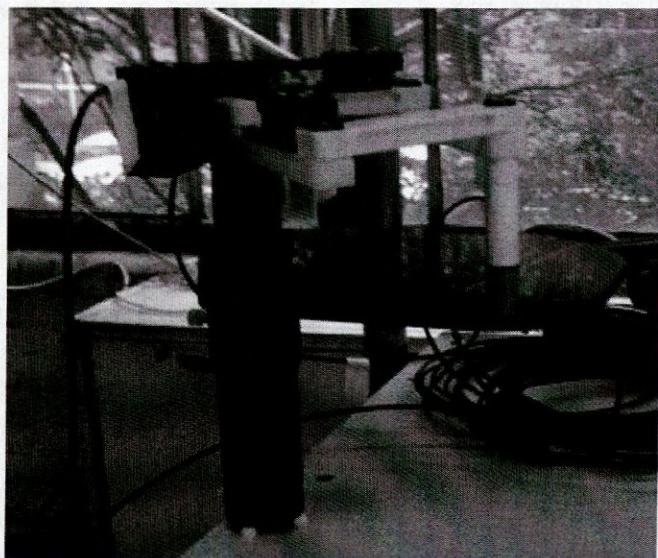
A two DOF MRI-compatible haptic device. Courtesy of Fabrizio Sergi.
